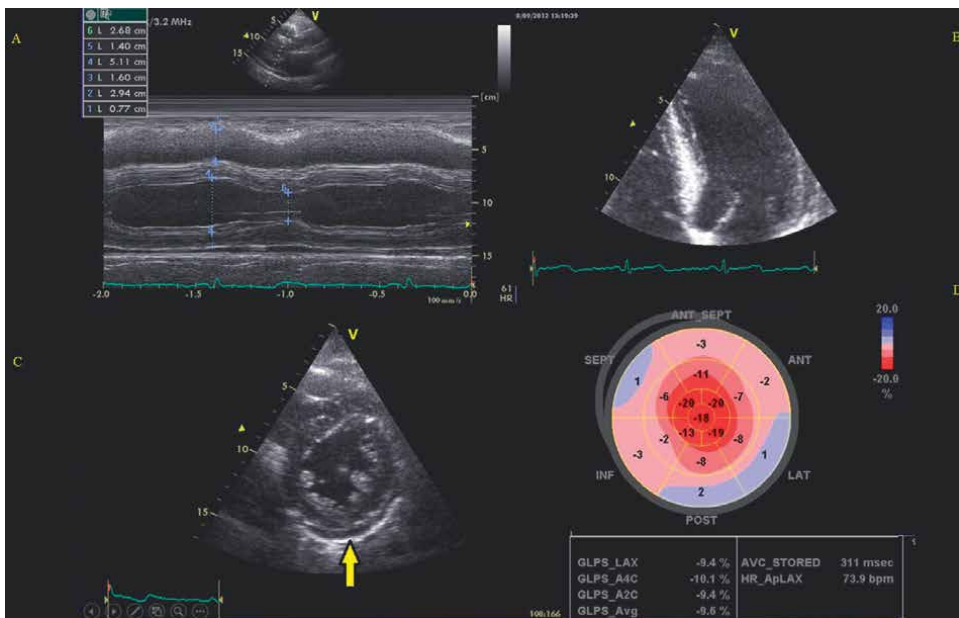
Echocardiographic characteristics of a patient with amyloidosis. A: Long parasternal view, M-mode on the left ventricle, which has a thickness (> 12 mm). B: Four-chamber apical view, granular sparkling of myocardium. C: Parasternal short axis view, pericardial effusion (arrow). D: Longitudinal echocardiography strain depicted in bull's-eye map showing preserved apical strain (apical sparing) with reduction of mid and basal strain that results in hallmark “cherry on the top” pattern.
